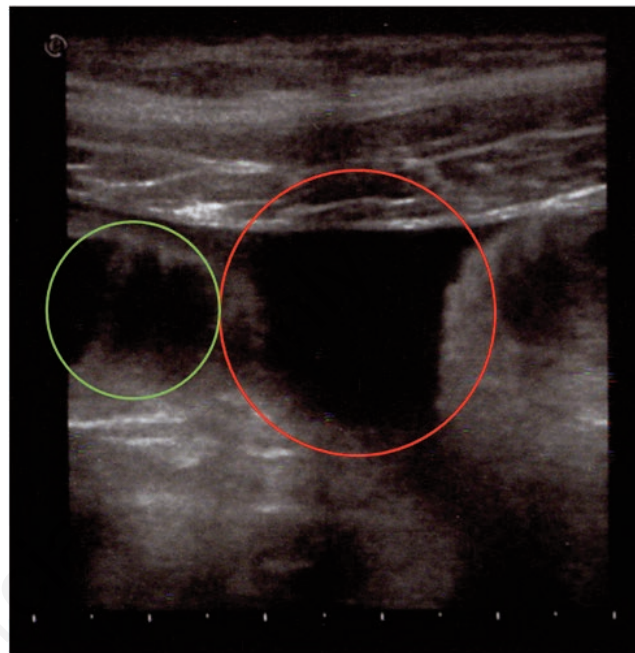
Abdominal ultrasonography: dilated fluid-filled loops greater than 2.5 cm in diameter of the small bowel (green circle) and presence of free abdominal fluid between the intestinal loops (red circle).
